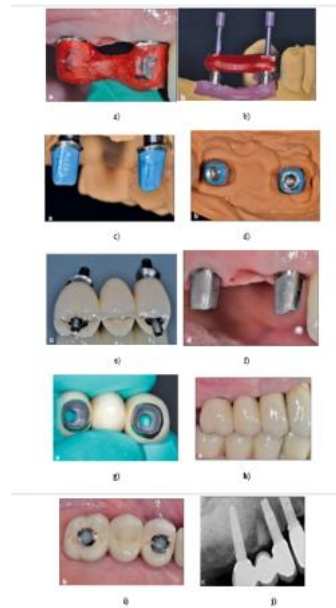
(a) Prefabricated trial cementation jig used to assess implant angulation and determine the appropriate ISFPD design during the custom abutment try-in stage. (b) Two splinted impression copings on the master cast before removal. (c) Die spacer applied on custom abutments, avoiding the cervical region to maintain a primary cervical cement seal and reduce risks of cervical cement degradation. (d) A 0.5–1 mm zone around the abutment screw-access channel was left uncoated to establish a secondary occlusal cement seal and prevent coronal cement film breakdown. (e) Final porcelain fused to metal SRCR ISFPD components with engaging abutments. (f) Titanium milled custom abutments sandblasted (excluding finish line) and placed intraorally for cementation. (g) Intaglio surface of the sandblasted ISFPD prior to cementation. (h) Lateral clinical view of the final SRCR ISFPD. (i) Occlusal clinical view of the definitive prosthesis. (j) Final radiograph showing completed ISFPD in position.
